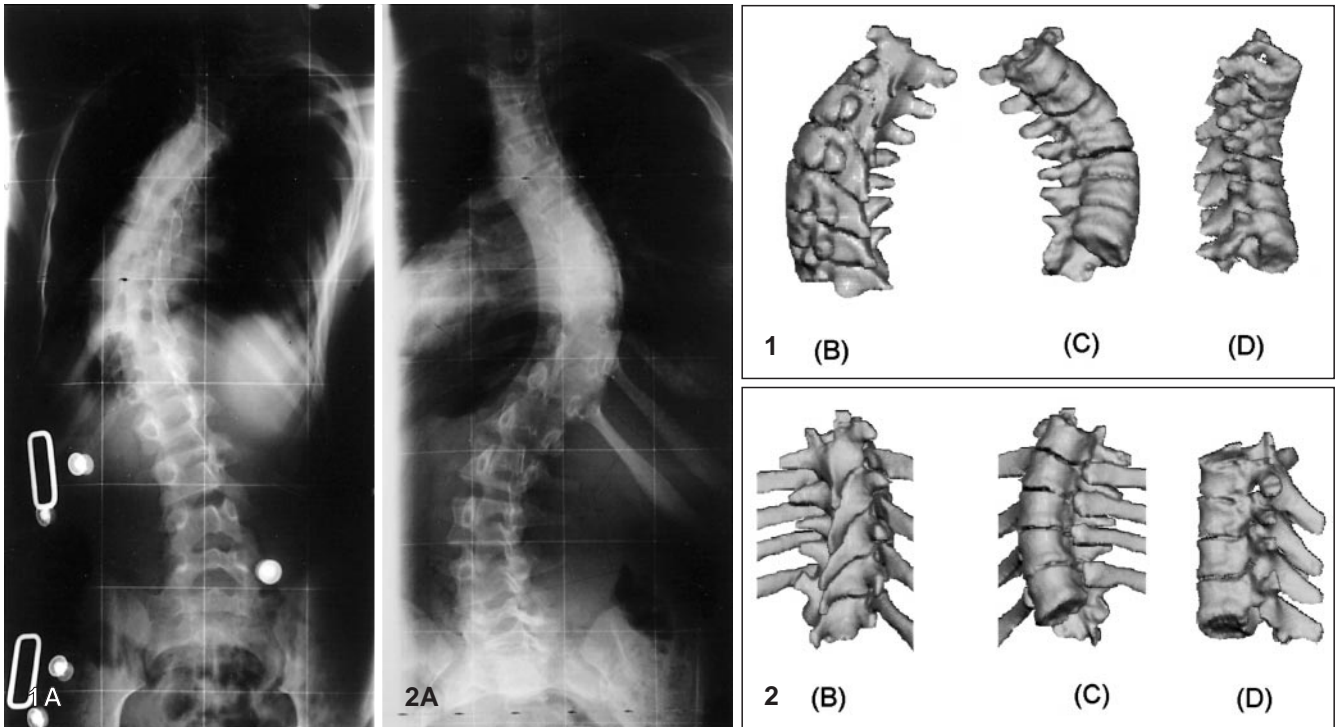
Standing anteroposterior spinal radiograph (A) and posterior (B), anterior (C) and lateral (D) views of the 3-D CT reconstructions of the thoracic scoliotic segment of the first patient
